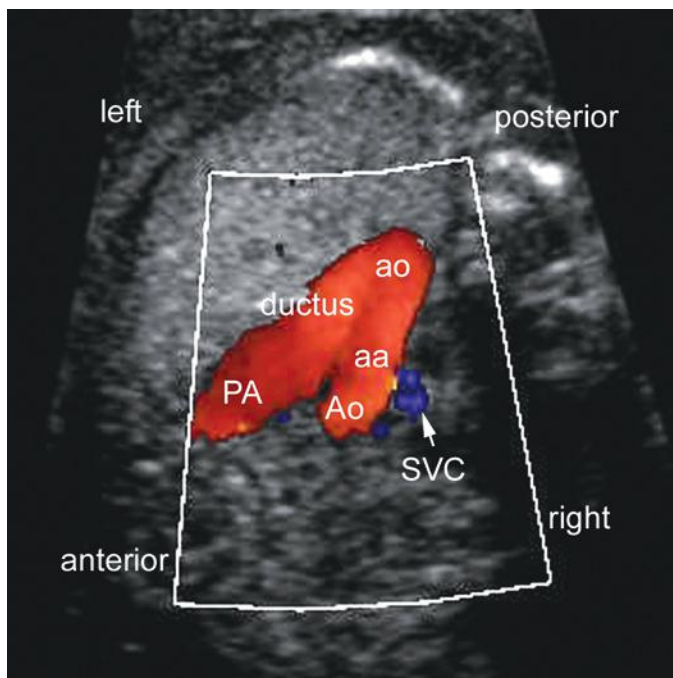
Three-vessel and trachea view using color Doppler imaging. aa, aortic arch; Ao, ascending aorta; ao, descending aorta; DA, ductal arch; PA, pulmonary artery; SVC, superior vena cava.
